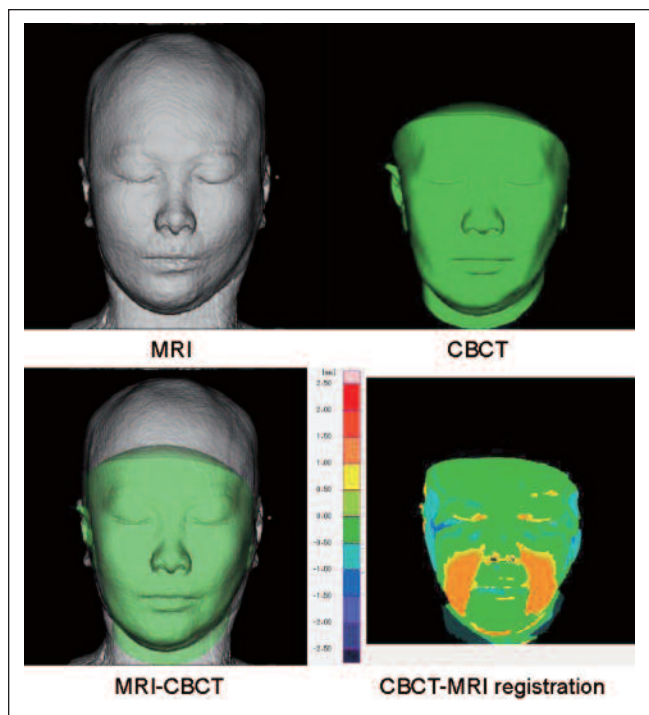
CBCT-MRI superimposition and registration. The pale green area shows that superposition (or registration) was performed within ± 0.50 mm. The yellow area shows it to range from $+0.50$ mm to $+1.00$ mm. The light blue area shows it to range from -0.50 mm to -1.00 mm.
